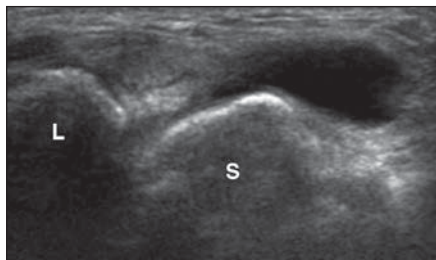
38-year-old woman with ganglion of dorsal wrist. Gray-scale ultrasound image of wrist shows simple cyst arising from between scaphoid (S) and lunate (L) of dorsal wrist.
